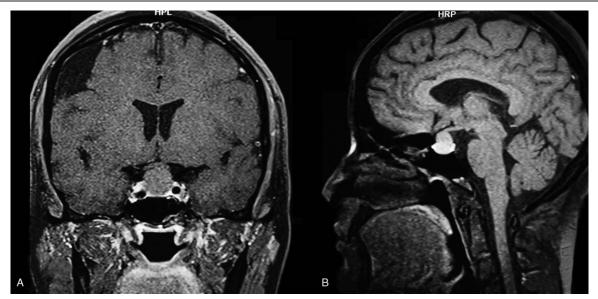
Preoperative magnetic resonance imaging features of primary Rathke's cleft cyst before initial transsphenoidal surgery on March 2016. An oval cystic mass was seen in the sellar region (size: 11.1 mm × 17.8 mm × 15.8 mm), which displayed inhomogeneous enhancement on coronal (A) and sagittal (B) T1-weighted post-gadolinium images.
